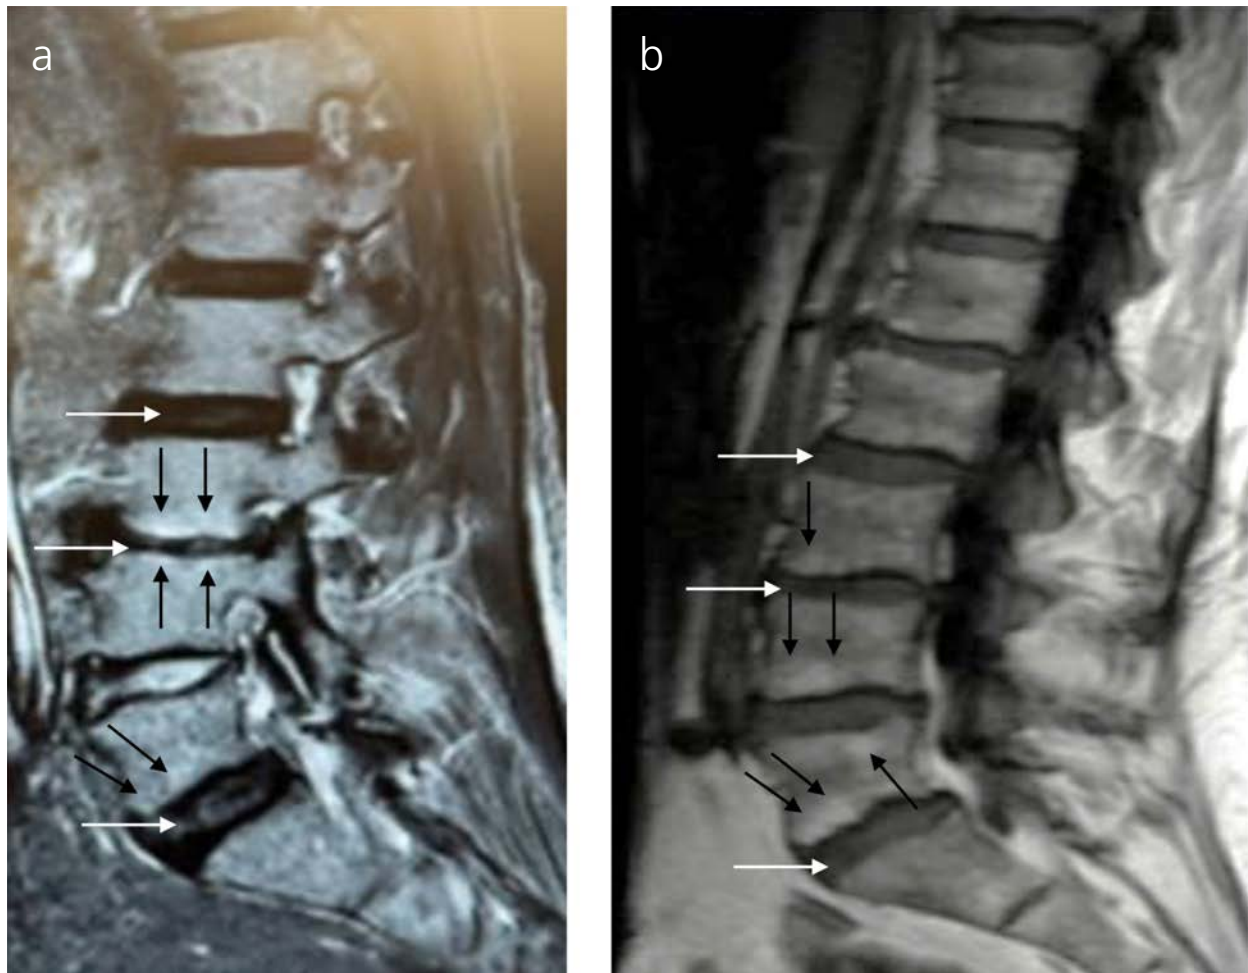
Lumbar spine MR images demonstrating degenerative disc disease (white arrows in a and b) and degenerative endplate (Modic) changes (black arrows in a and b). Sagittal STIR (a) and T1-weighted (b) images demonstrate multilevel degenerative disc disease characterized by disc height loss and endplate irregularities, with associated Modic type 1 and type 2 endplate changes consistent with vertebrogenic and discogenic pain generators.
